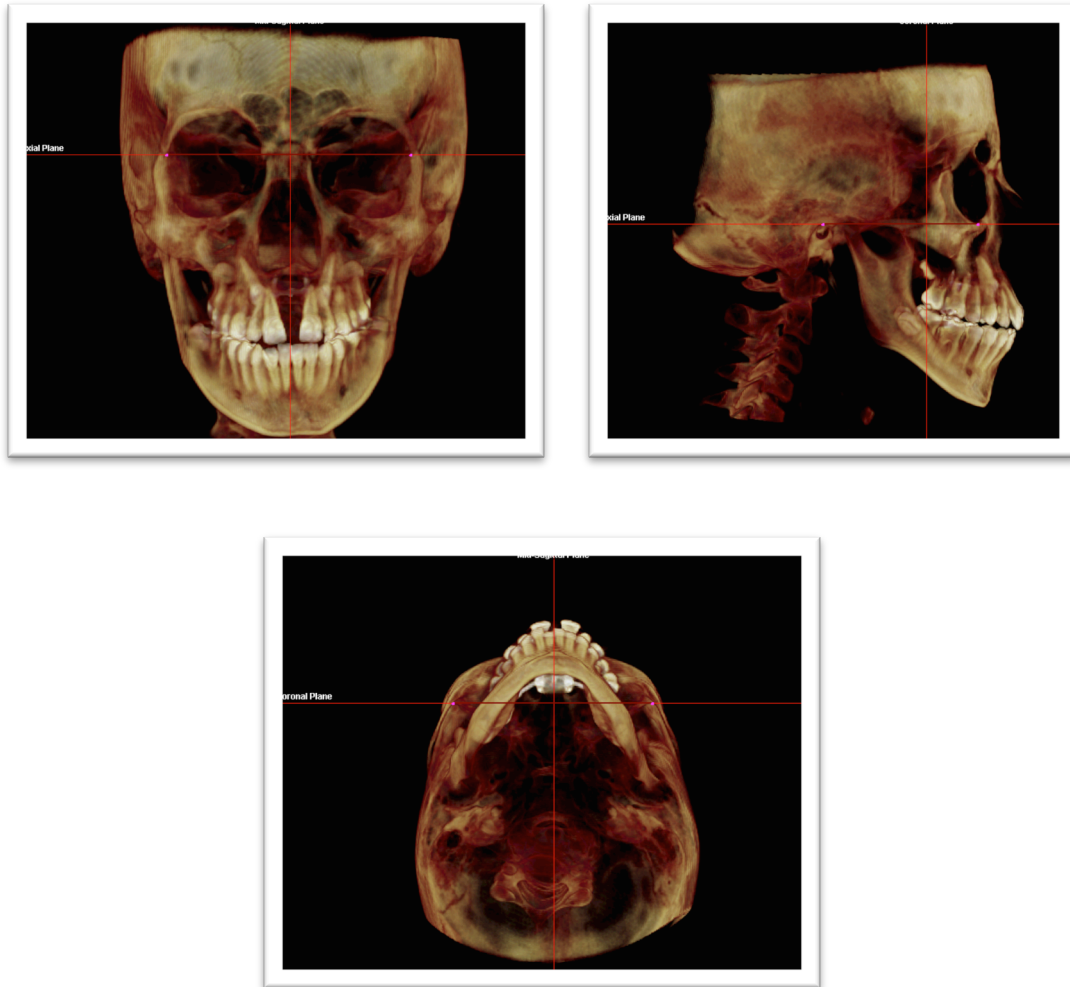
CBCT Orientation – Coronal, Sagittal, Axial
